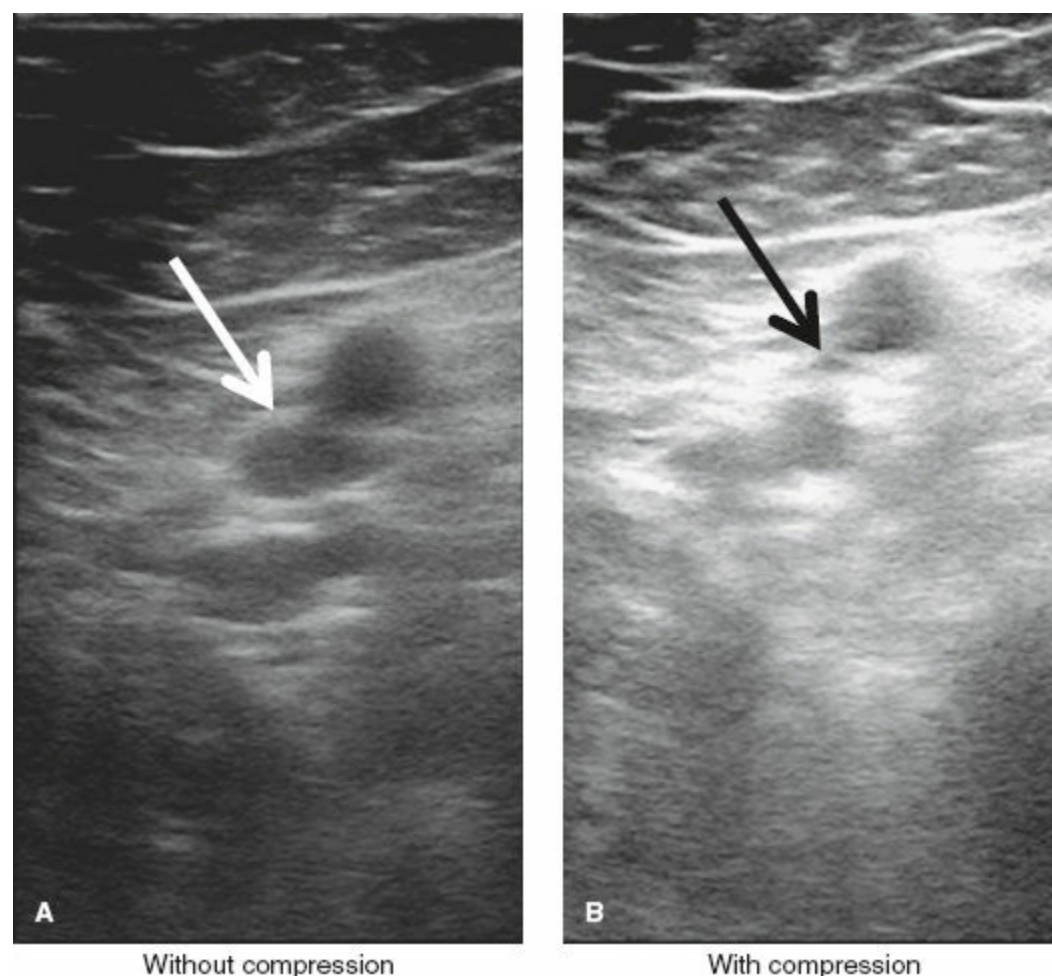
A: Without compression with the ultrasound probe the femoral vein is easily visible (*white arrow*). B: With compression the vein collapses and is no longer visible (*black arrow*). Failure of the vein to collapse with probe pressure would indicate the presence of thrombus within the vein.
